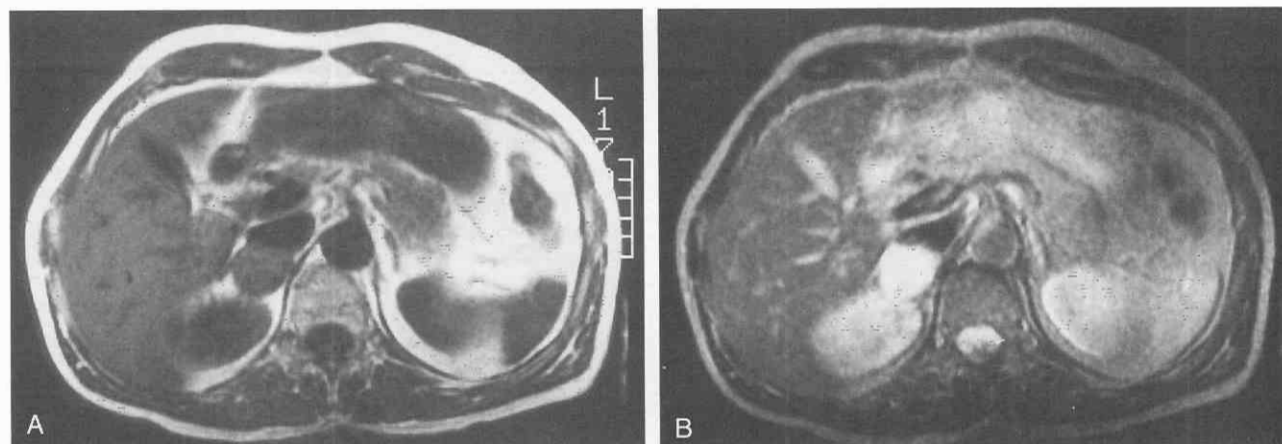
Pheochromocytoma. *A* and *B*, MR scans of a 3.5-cm solid right intra-adrenal pheochromocytoma. On T2-weighted images, this tumor demonstrates the hyperintense signal intensity commonly seen in intra-adrenal pheochromocytomas.
